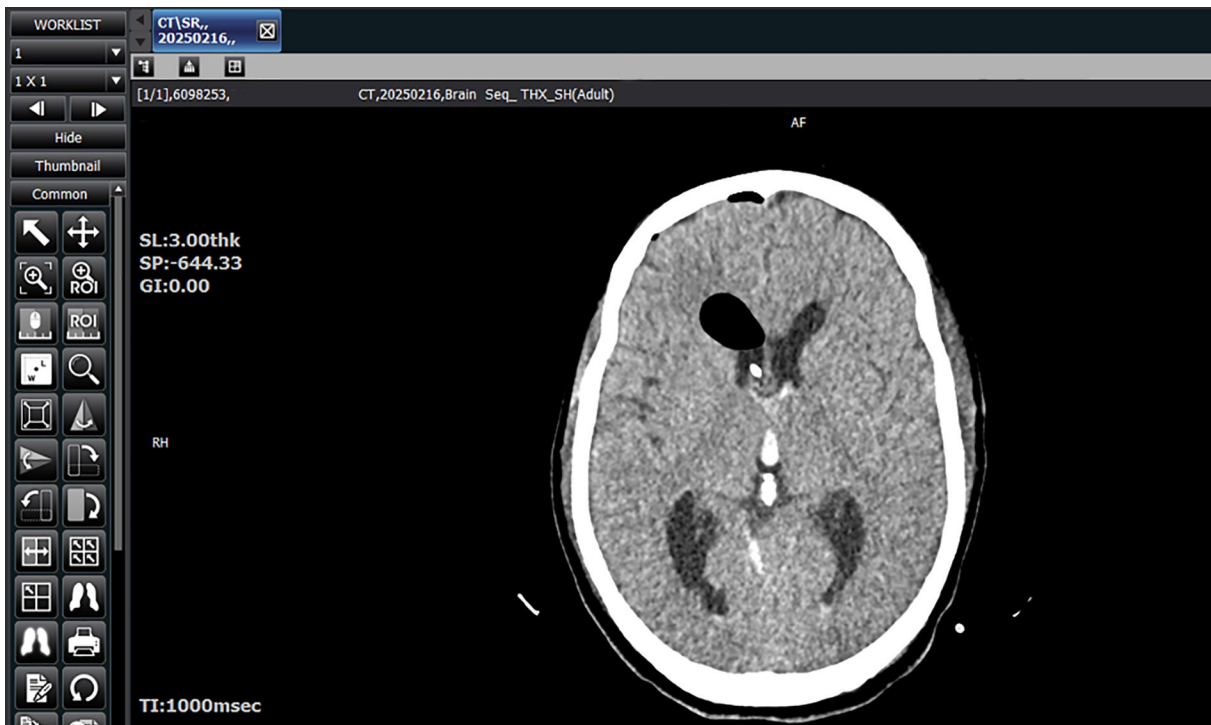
The figure shows brain CT scan performed postoperatively following tumor resection.
